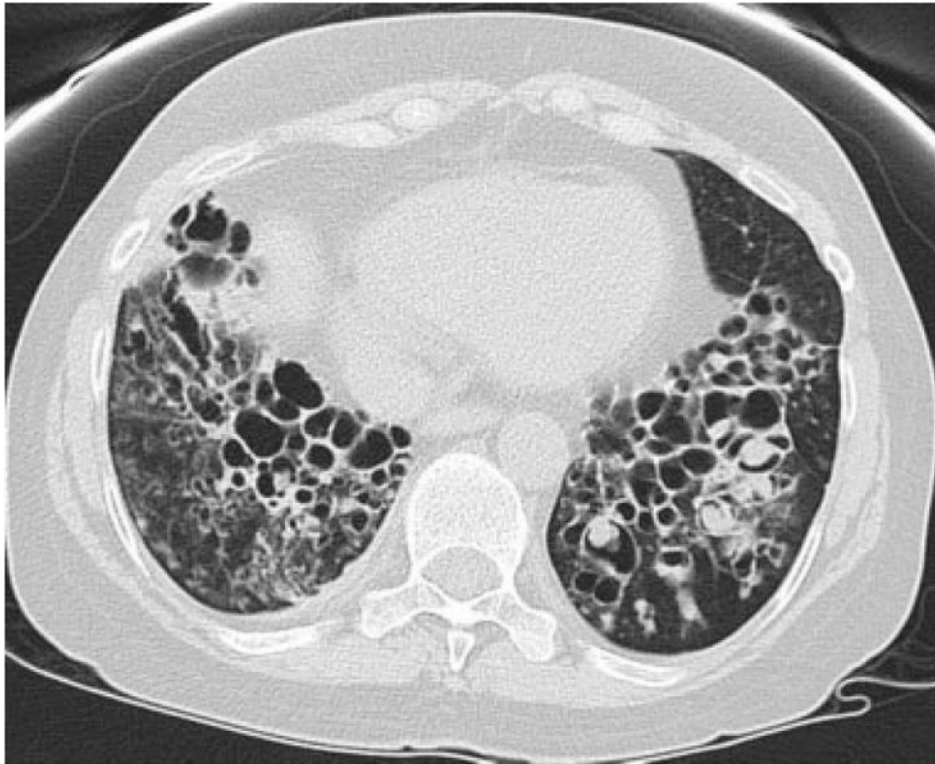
Chest CT of a 56-year-old woman with cystic fibrosis that demonstrates multiple mycetomas occupying ectatic airways, most prominently in the left lung.
